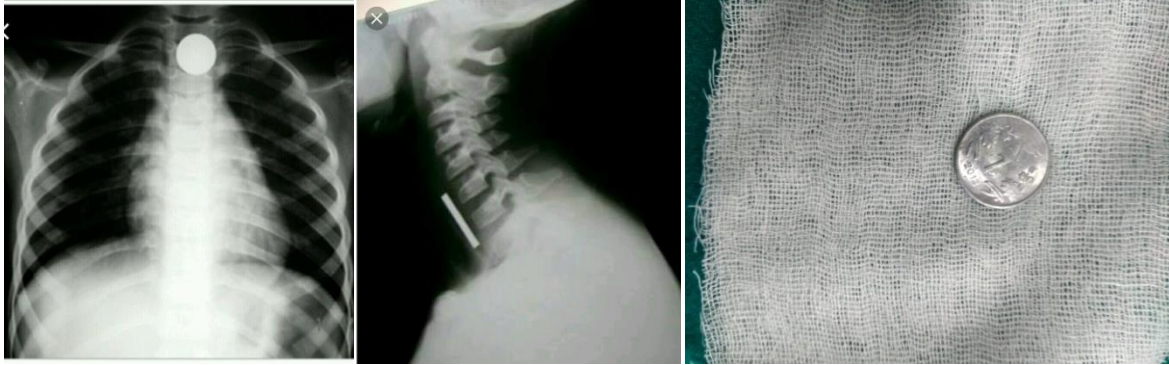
shows Xray Neck /chest A/P and Lateral view showing coin at the level of cricopharynx along with removed coin.
